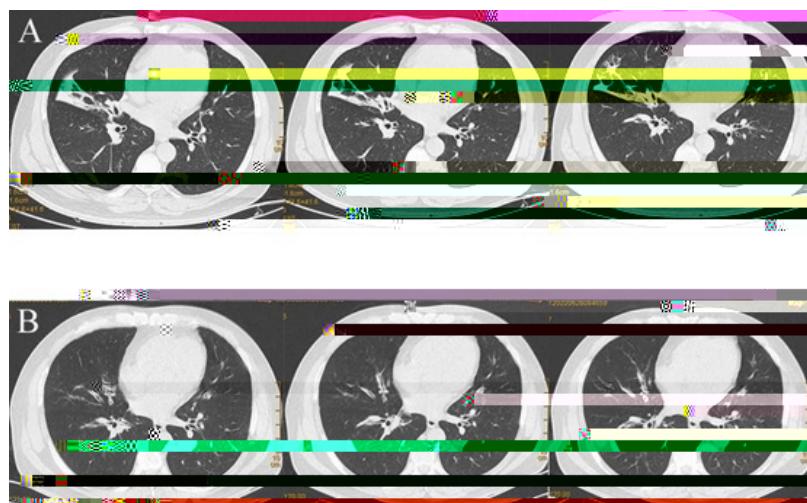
A. Chest CT shows lung shadows before treatment; B. Chest CT shows no shadows in the lung after treatment.
